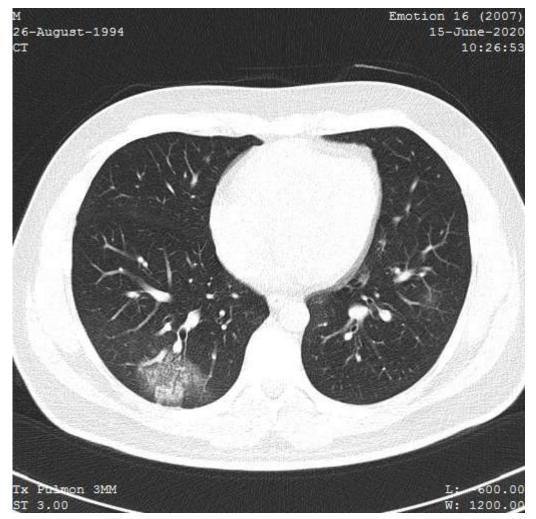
Chest CT-scan of a 26-year-old man with confirmed COVID-19 pneumonia. Representative axial thin-section chest CT image showing focal ground-glass opacity with reticular septal thickening. A total Computed Tomography Severity Index of 3 was calculated.
